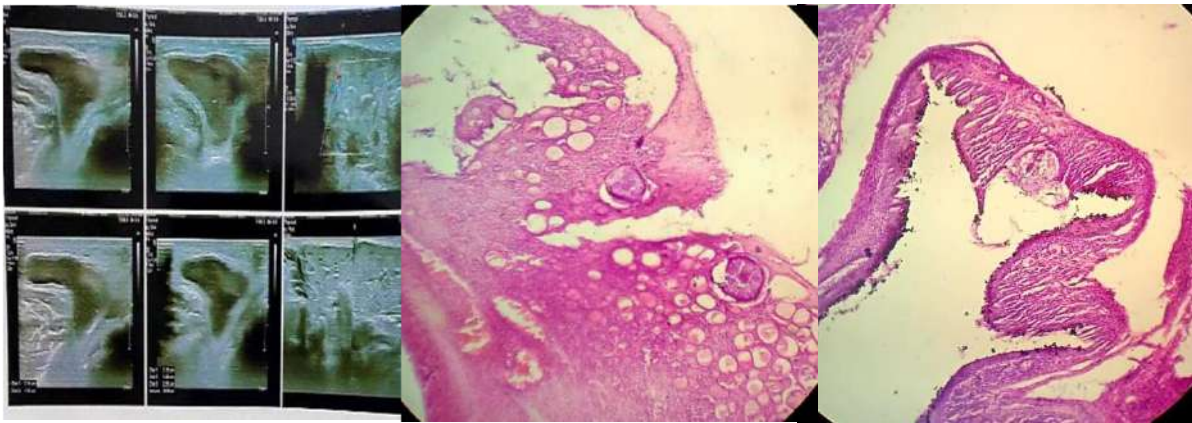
Ultrasound show a hypoechoic anechoic cyst within Right Parotid gland; Figure 13,14: H & E(4x) Parotid tissue showing multiple sporangia of varying sizes
